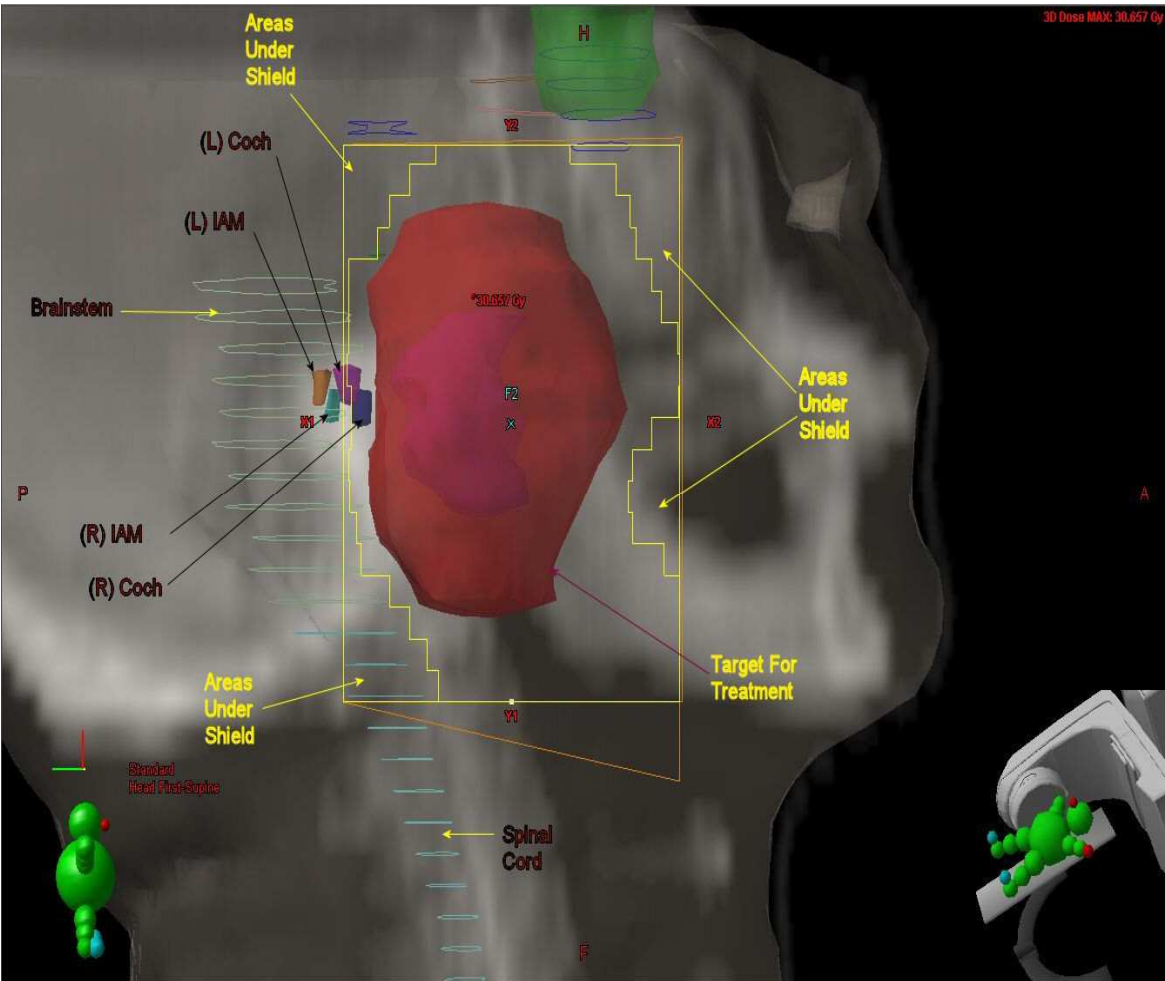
Beam's Eye View (BEV) of lateral post-nasal space field. The field (yellow box) is superimposed on a digitally reconstructed radiograph (DRR) by the planning computer. The solid red area represents the target volume where a uniform high dose is deposited. Critical structures are shielded to reduce exposure. These structures include the brain stem and spinal cord, optic chiasma (blue), and the inner ear as much as is feasible.
